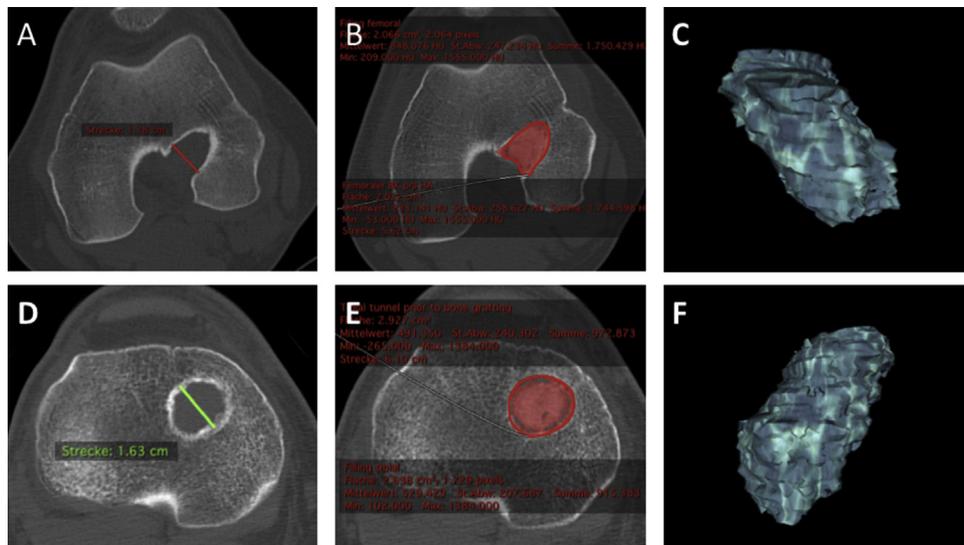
Dimensions of the preexisting tunnels and filling results after autologous bone grafting as revealed by CT scans. Maximum diameter and volume of the preexisting femoral (A, C) and tibial tunnels (D, F) were determined. Based on the postoperative CT scan, the volumes of the grafted bone and subsequently the filling rates were calculated for the femoral (B) and the tibial tunnel (E).
